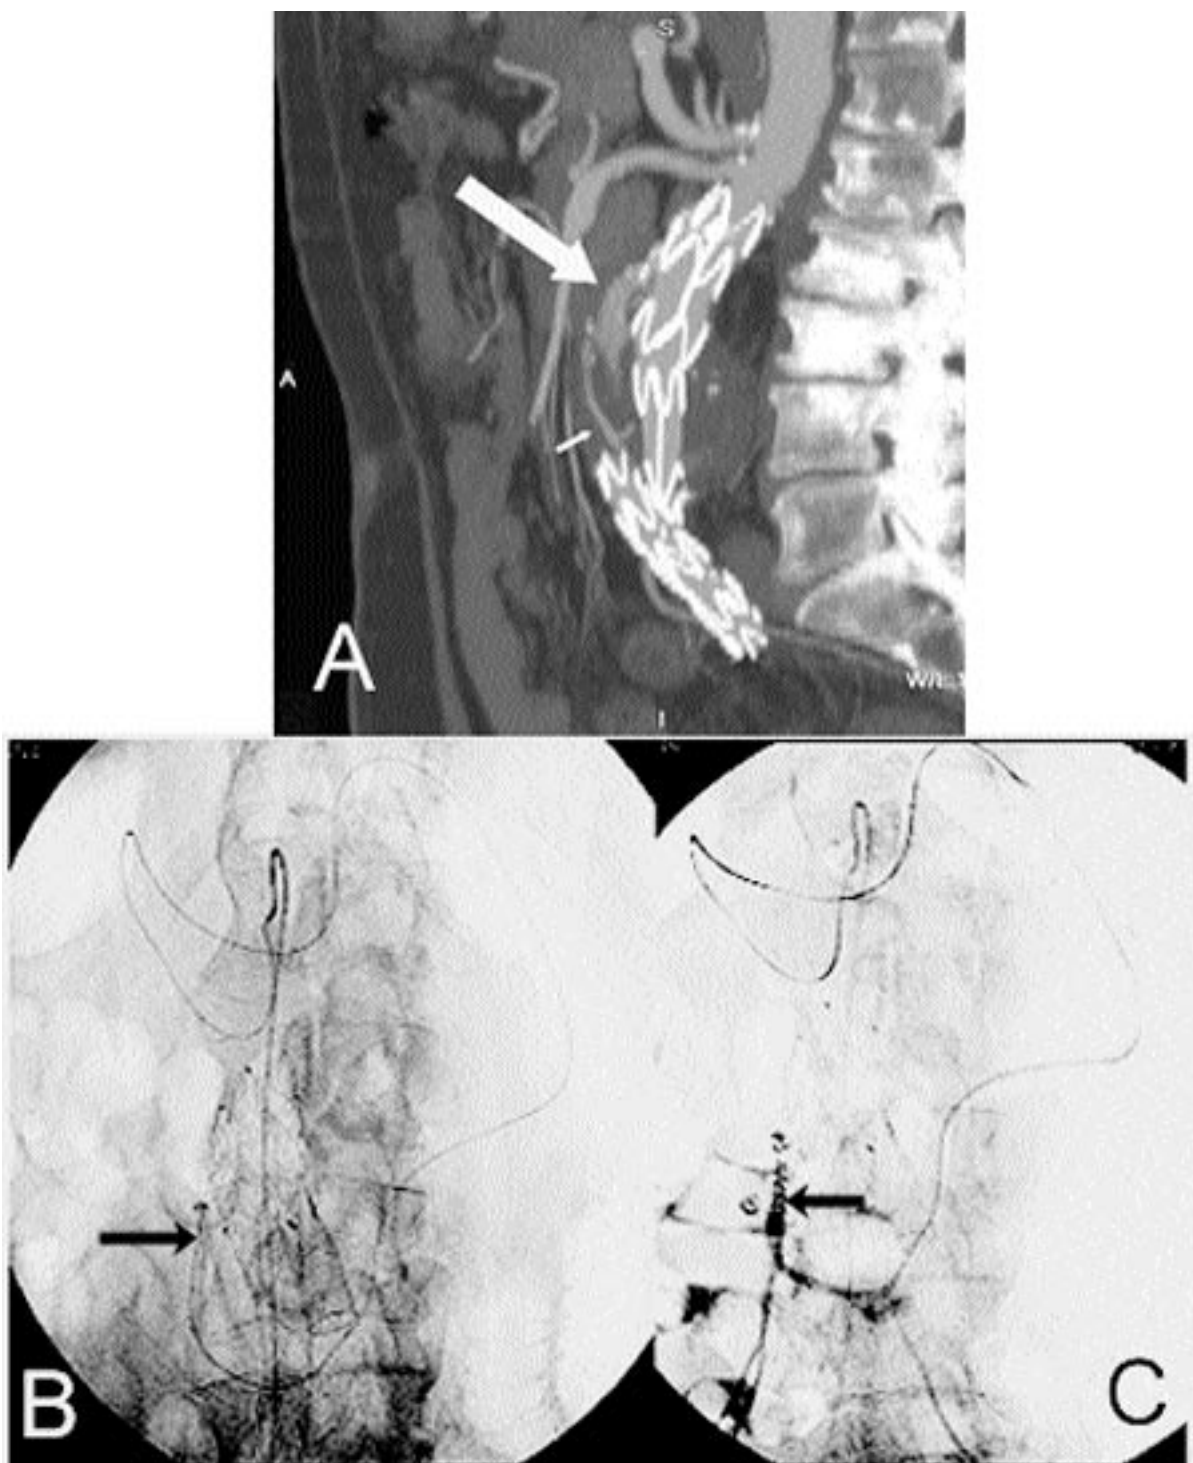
(A) Sagittal reformat of a multidetector CTA of a patient who has undergone endovascular repair of an infrarenal abdominal aortic aneurysm. There is an endoleak (large arrow) anterior to the stent-graft. The leak is in continuity with the inferior mesenteric artery (small arrow), suggestive of a type 2 leak. (B) Angiography after selective catheterization of the inferior mesenteric artery (arrow) from the superior mesenteric artery via the arc of Rioloan. (C) Following embolization of the inferior mesenteric artery at its origin (arrow) off the aneurysm, there is no inflow to the endoleak.
